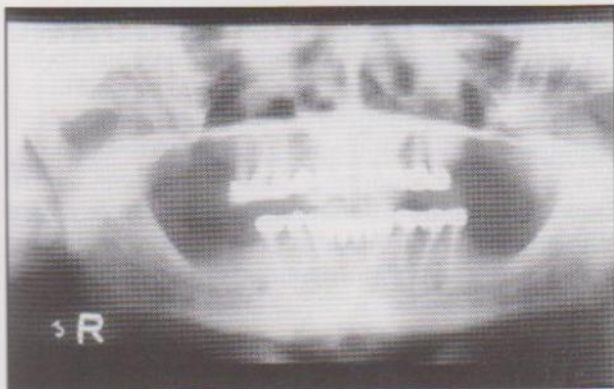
Post-operative panoramic x-ray.
